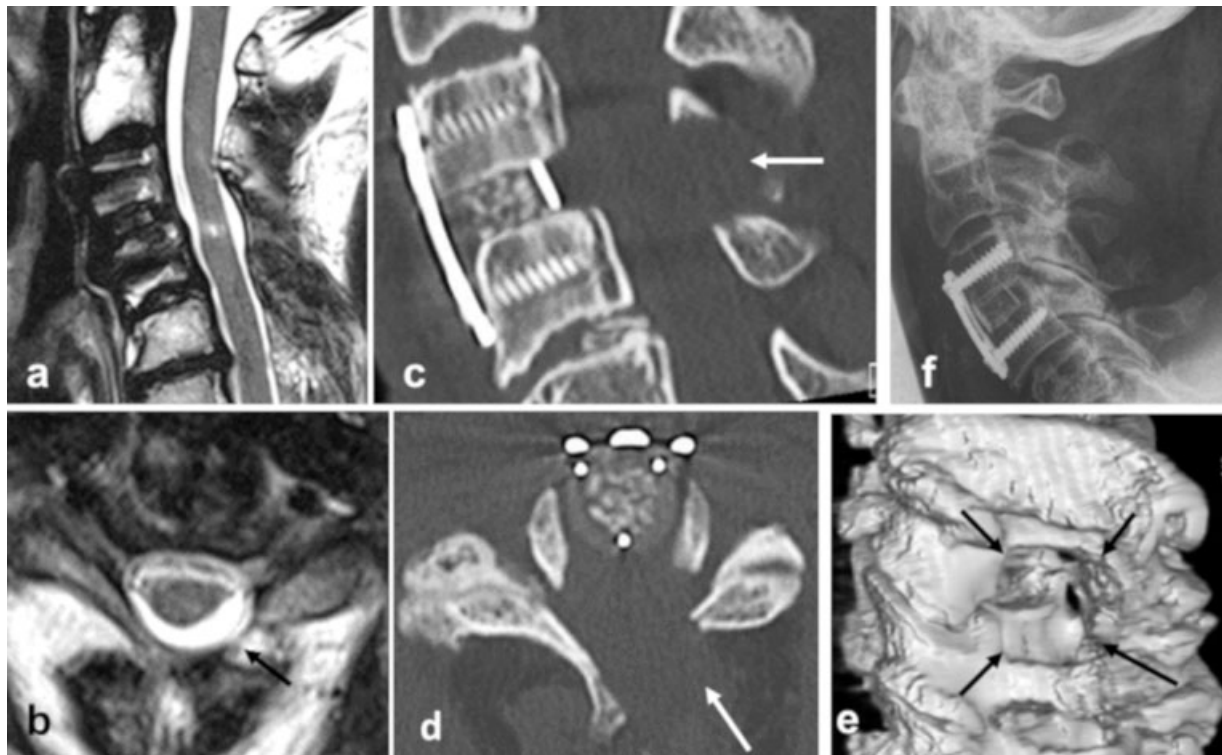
Postoperative imaging of a microsurgical 360-degree procedure (m360°). (a) Magnetic resonance imaging (MRI) shows adequate decompression at C3/C4, with persistent intramedullary signal hyperintensity. Nevertheless, the modified Japanese orthopaedic association (mJOA) score improved to 16.5. (b) MRI shows the left-sided approach (arrow) of the crossover decompression. Reformatted computed tomography (CT) scans show (c) the cage filled with autologous bone, the anterior plate, and the dorsal bone window (arrow) and (d) the left-sided laminar window (arrow). (e) 3D-CT shows the extent of the bone window (four arrows). (f) X-ray image shows the postoperative lordotic alignment of the index level.
